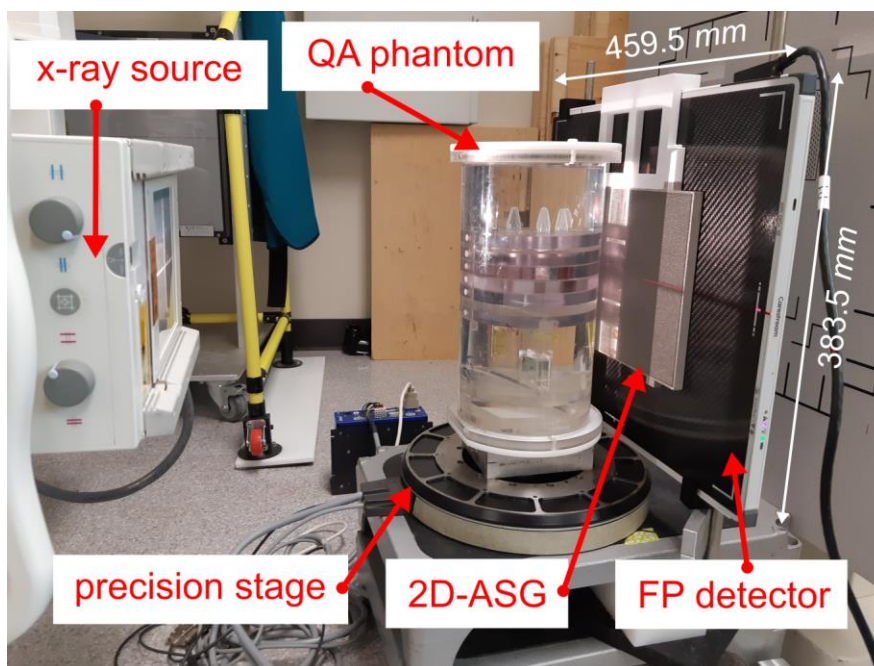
Custom, stationary-source, CBCT experimental setup. Ceiling-mounted x-ray unit, precision rotary stage, 2D-ASG, and flat-panel digital detector.
